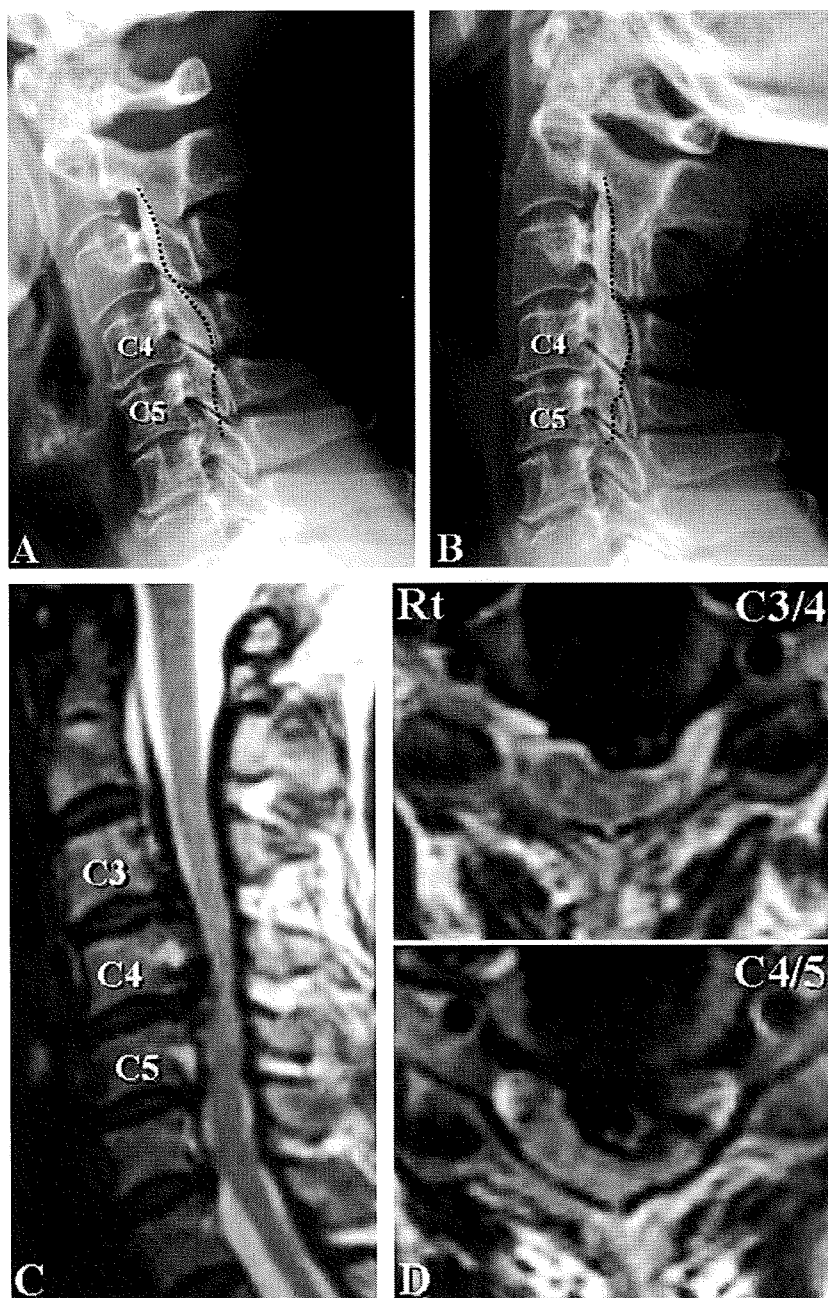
(A) Flexion and (B) extension cervical radiographs at the initial visit of a 65-year-old woman with continuous type ossification of the posterior longitudinal ligament (OPLL) (patient 1) showing that the segmental range of motion was 1 degree at C4/5. T2-weighted (C) mid-sagittal and (D) axial MRI indicated anterior compression of the spinal cord at multiple levels, but high signal change was not apparent.
